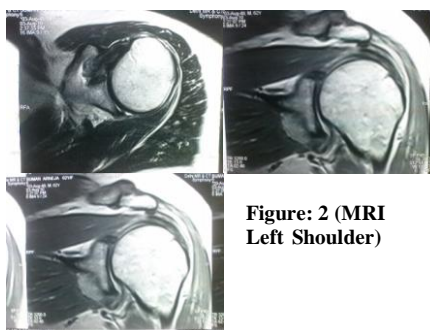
2 (MRI Left Shoulder)
